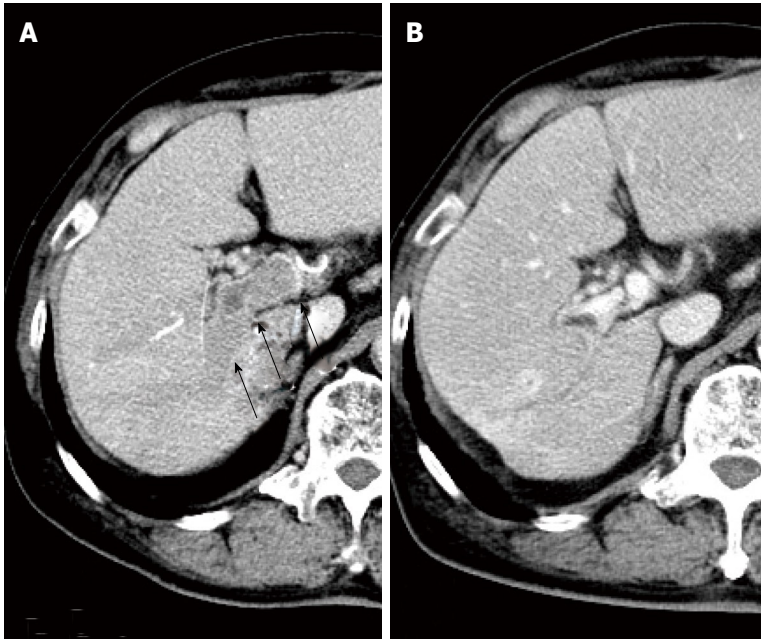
Abdominal computed tomography. A: Portal vein tumor thrombus (PVTT) extends to the major trunk (arrows) before intra-arterial infusion of 5-FU (FAIT); B: After four courses of FAIT, PVTT clearly disappeared and the portal vein becomes vacant.
